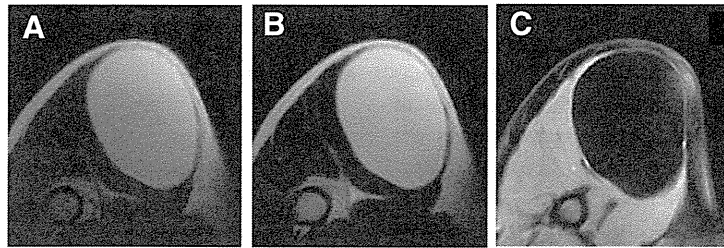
A 34-year-old male patient with a lipoma measuring 12 cm in diameter. Axial T1- and T2- weighted MRIs showed a homogenously high intramuscular mass (A, B). T1-weighted fat saturation gadolinium-enhanced MRI showed no enhancement of the tumor (C). This case obtained 2 points using the ALT score.
